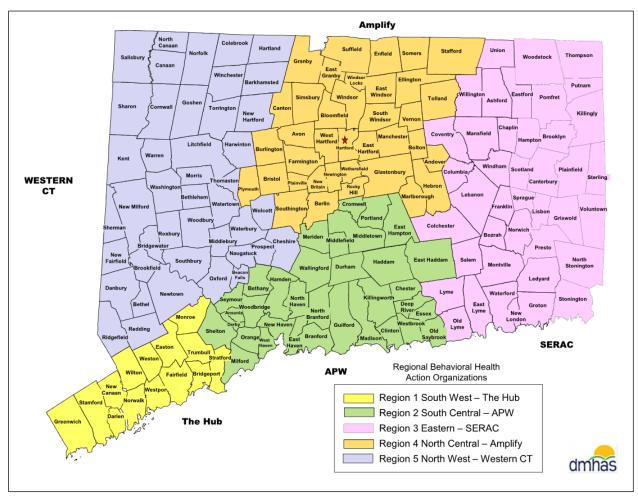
Figure AL-3. CT Regional Behavioral Health Action Organizations (RBHAOs)
